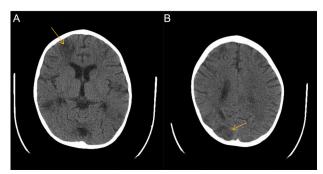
Patient's CT scan five days after the first seizure shows hypodense lesions in frontal lobe (arrow in A) and parietooccipital lobe (arrow in B) which are typical findings in PRES.
